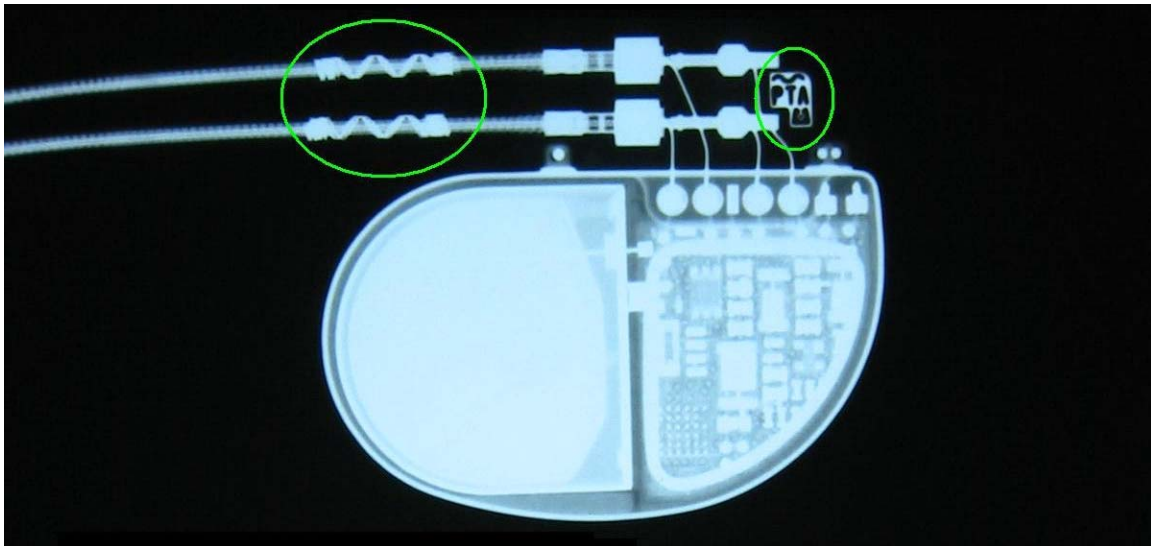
X-ray image of MRI labeled device with radiopaque symbols on the lead and IPG, indicating a complete MR Conditional system.
